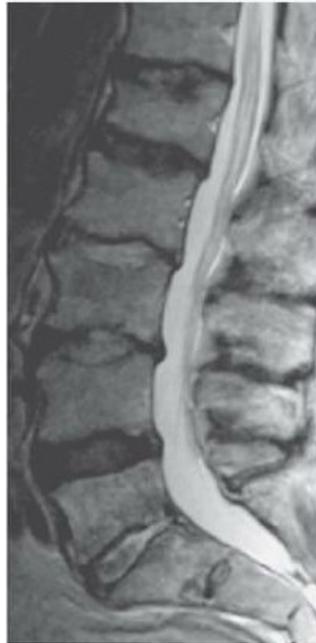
T_2 -weighted MR image of the lumbar spine [28]
